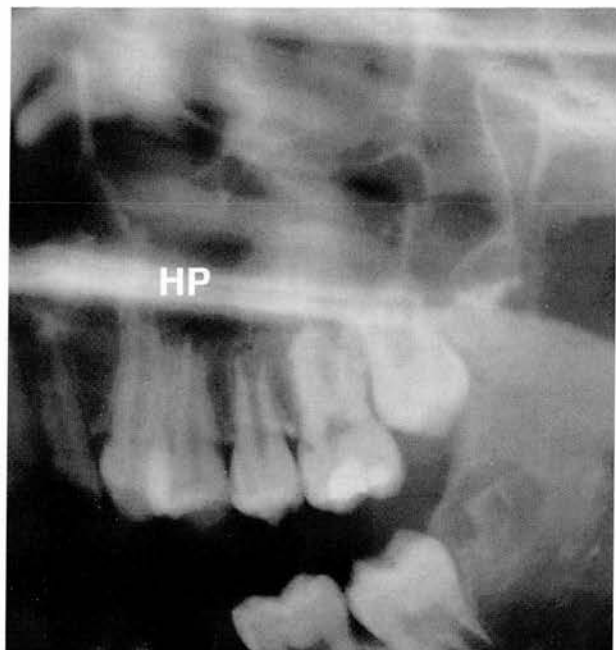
Part of a panoramic radiograph showing a mucosal antral cyst (MAC). Although a soft-tissue structure it is visible in the air-filled maxillary antrum by virtue of the "silhouette sign". It has no cortex and the corticated normal antral floor is intact and undisplaced. The hard palate immediately adjacent to the alveolar process presents as two horizontal radiopaque lines. The upper line is the secondary image of that of the contralateral side.
